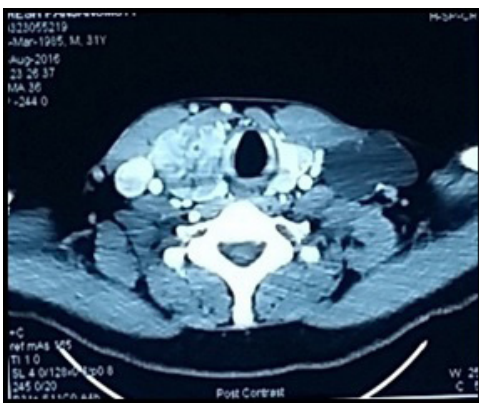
CT neck shows there were a hypoechoic lesion arising from both thyroid glands. The lesion in the right thyroid gland was measuring 4.5cm x 4.25 cm x 6.1 cm trachea was pushed to the left side.
